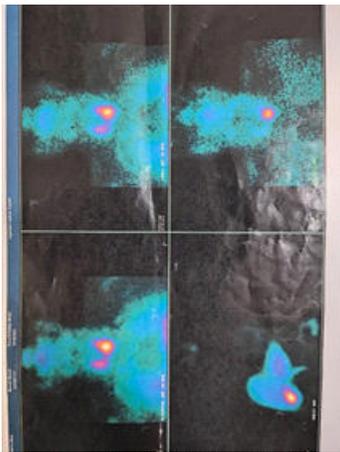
Planar 99mTc-sestamibi parathyroid scintigraphy
